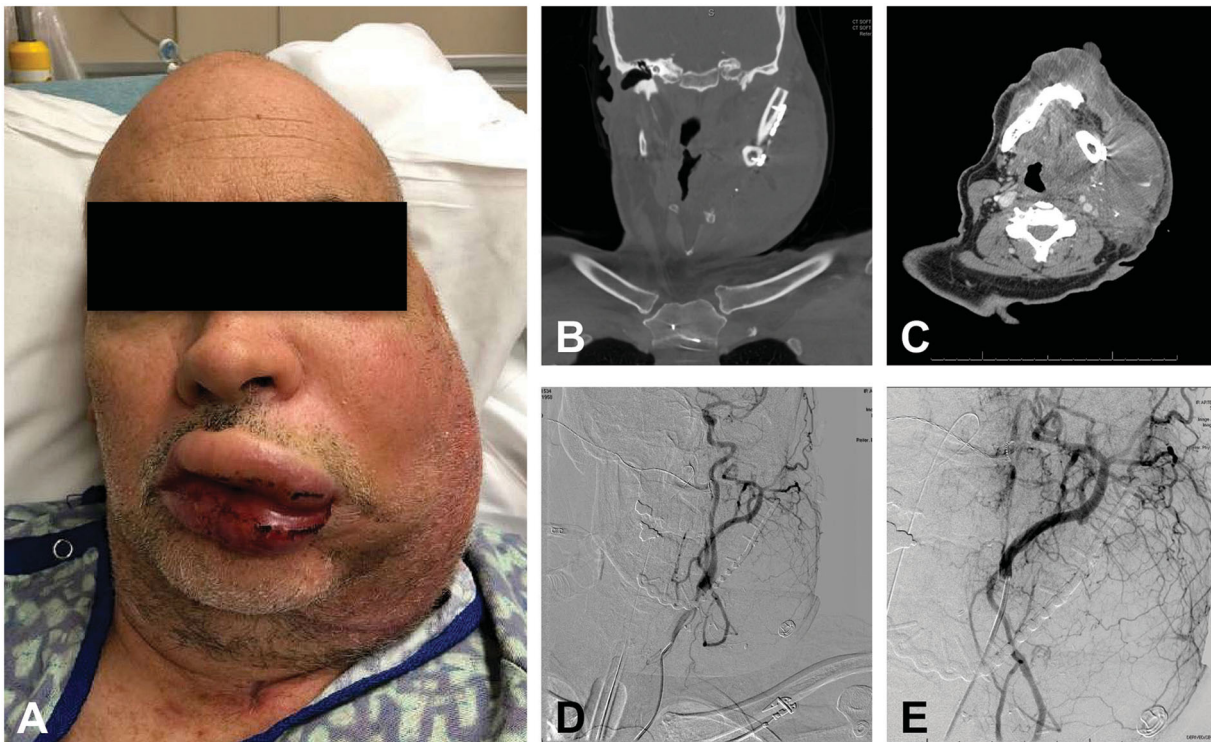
(A) Thirty days after his operation, patient consulted our emergency room complaining of progressive facial edema and difficulty swallowing. His INR on presentation was 2.49. (B–C) A CT scan of the neck with IV contrast was performed which showed a 9.1 cm hematoma lateral to the left mandible with an internal focus of hyperdensity concerning for active hemorrhage. (D–E) The angiogram demonstrated no evidence of active bleeding or suggestions of any potential bleeding site.
